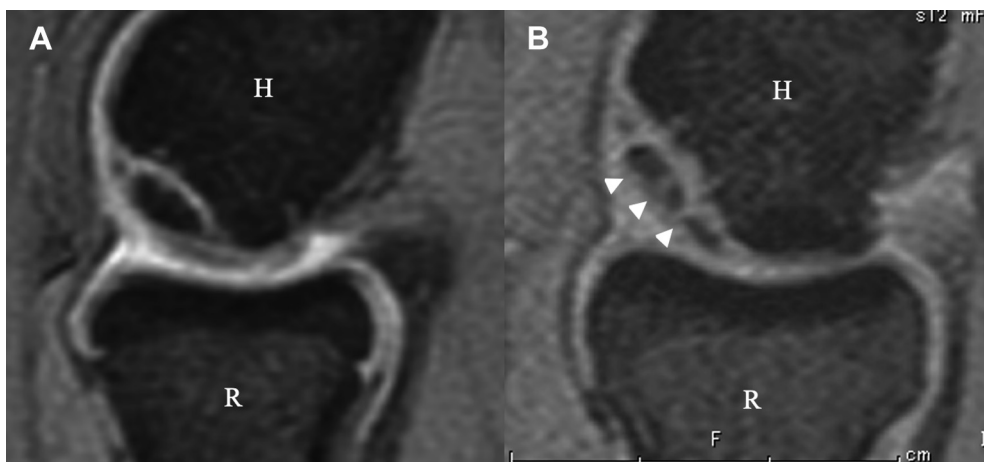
Sagittal MRI image of the elbow. (A) Capitellum of the humerus shows osteochondritis dissecans. (B) White arrowheads show segmentation of an osteochondral fragment. MRI, Magnetic resonance imaging; H, Humerus; R, Radius.
